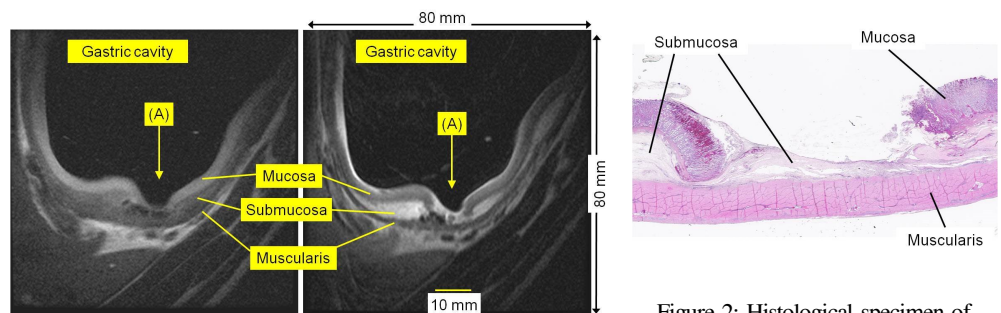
MR images of the gastric wall by the intracavitary RF coil; (left) T1-weighted image and (right) T2-weighted images. (A) indicates the defect of the mucosa and a part of the submucosa.
